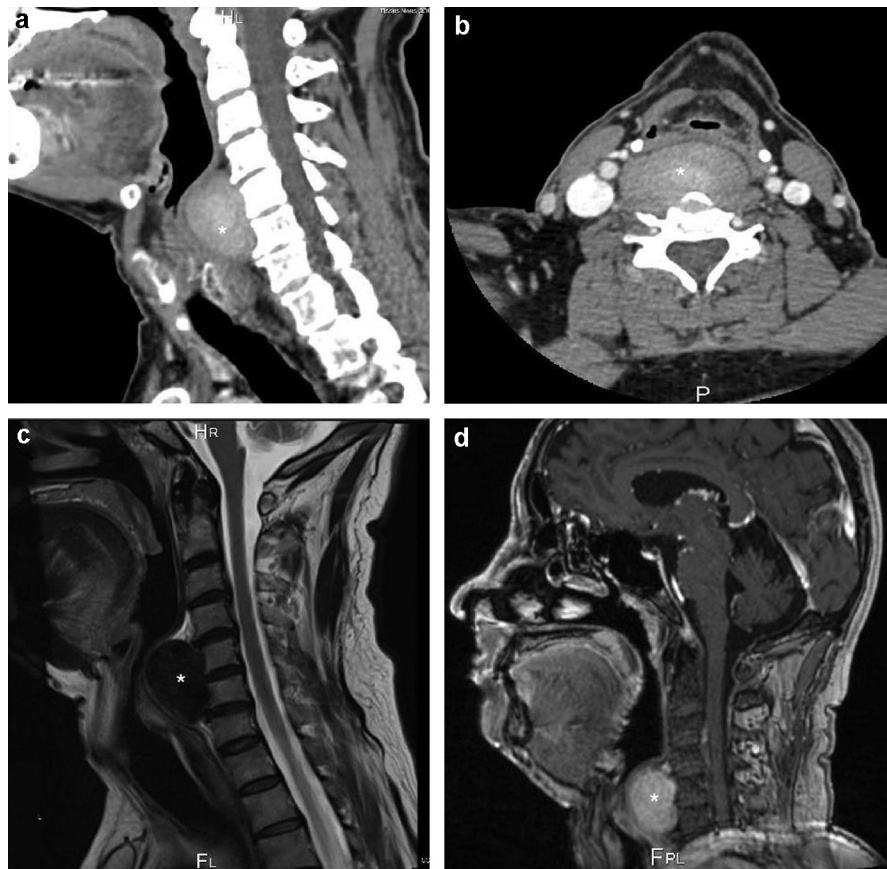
Imaging of the retropharyngeal neurofibroma (star). CT-scan sagittal section (a) and axial section (b) with contrast injection showing a prevertebral lesion with low contrast enhancement. T2-weighted MRI sagittal slice (c) showing the same lesion with low signal intensity. The lesion shows enhancement after gadolinium injection on T1-weighted MRI sagittal slice (d).
